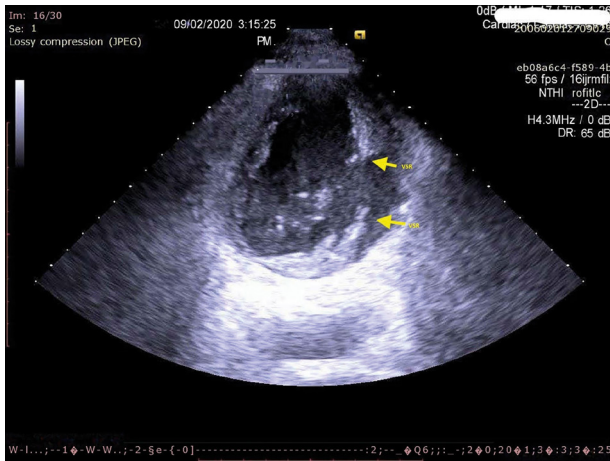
Modified apical four-chamber view of VSR of case 2.
